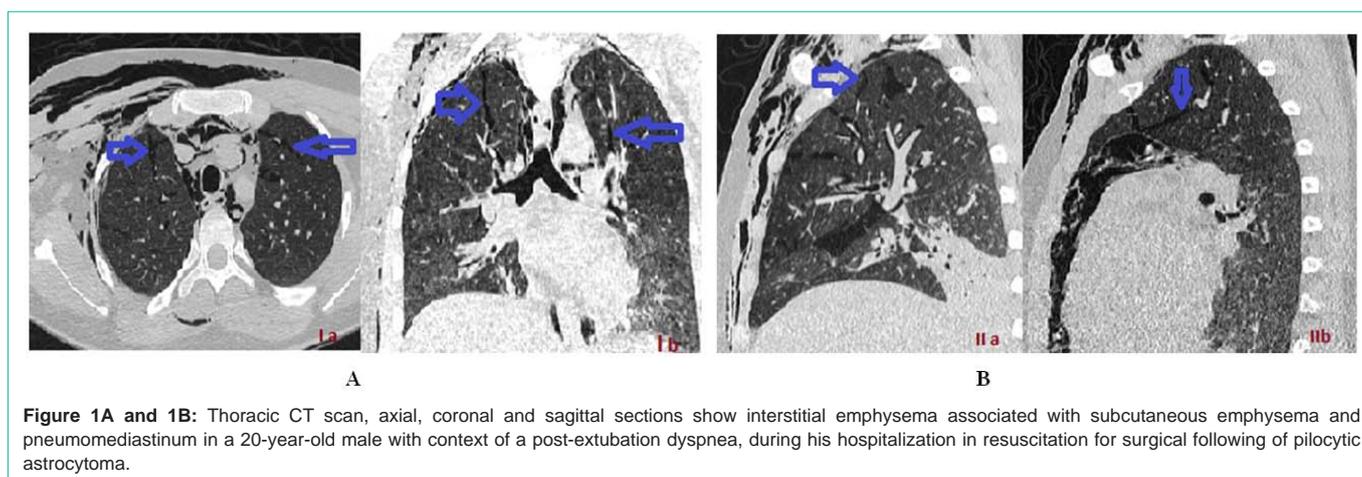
and 1B: Thoracic CT scan, axial, coronal and sagittal sections show interstitial emphysema associated with subcutaneous emphysema and pneumomediastinum in a 20-year-old male with context of a post-extubation dyspnea, during his hospitalization in resuscitation for surgical following of pilocytic astrocytoma.
